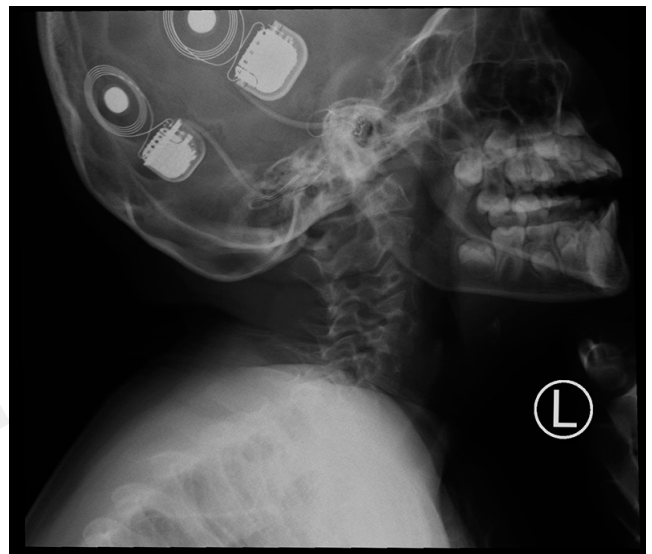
X-ray of the cervical spine- visible cochlear implants
